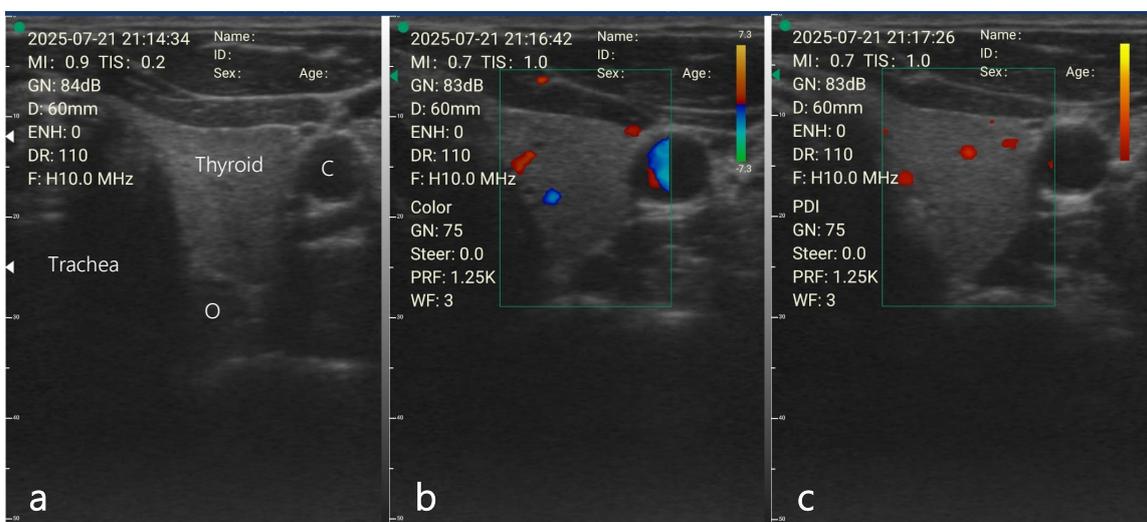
POCUS images of a normal thyroid with a) normal echotexture, b) normal Colour doppler and c) normal Power doppler. C - common carotid artery and O - oesophagus.
